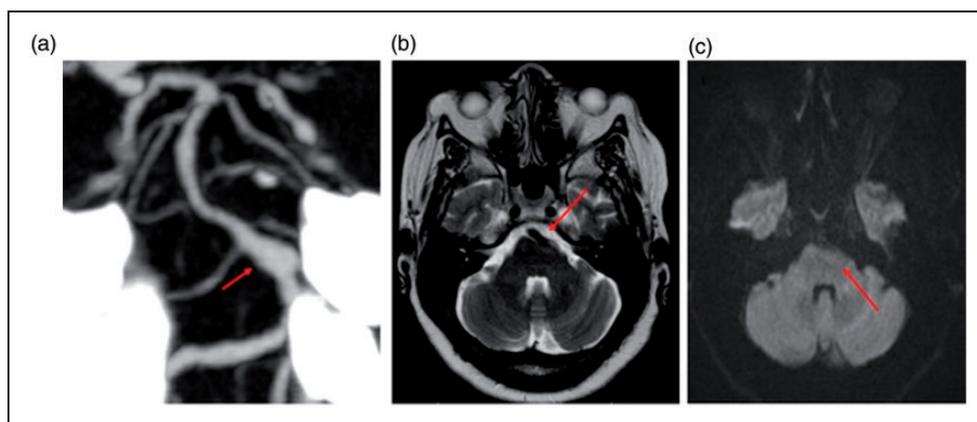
CT angiogram that shows dilated basilar artery at the level of the lower pons measuring 9x6.3 mm with the most prominent dilation overlying the left lower pons (a). MRI brain T2-sequence showing a flow void that corresponds to the basilar artery (white arrow) deforming the ventral surface of the pons (b), and on the diffusion-weighted images (DWI) we can see that there is no evidence of acute infarct (c).
